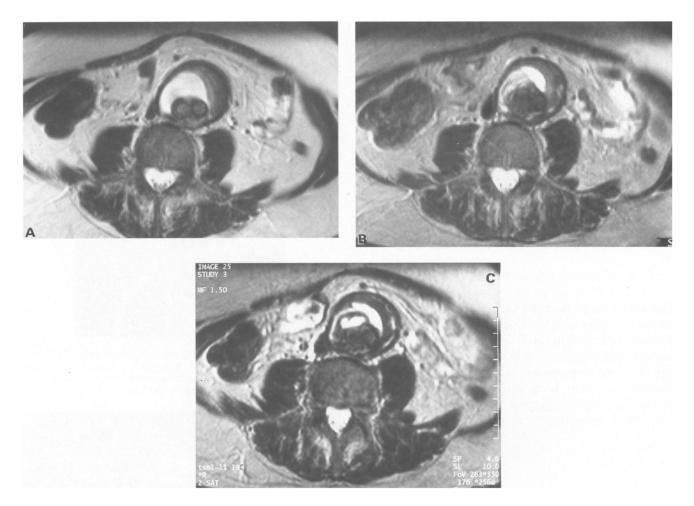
(a-c). Transverse T2-W MRI at (a) 1 month, (b) 6 months and (c) 12 months after stent-graft insertion showing increasing thrombus organisation.
